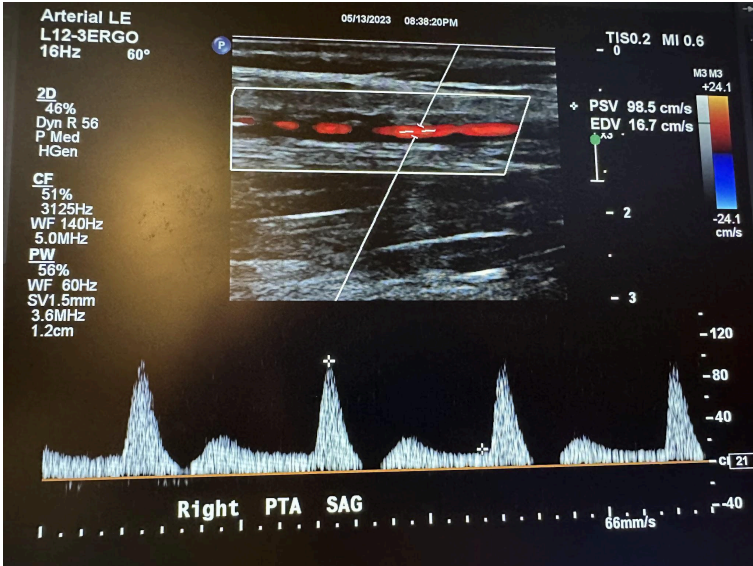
Sagittal image of the right posterior tibial artery with color Doppler and waveform analysis.
